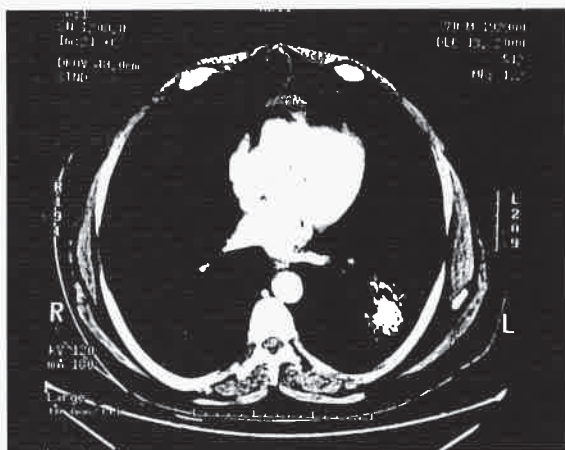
Computed tomography showing a heterogeneous mass in the left lower lobe with air bronchograms.
